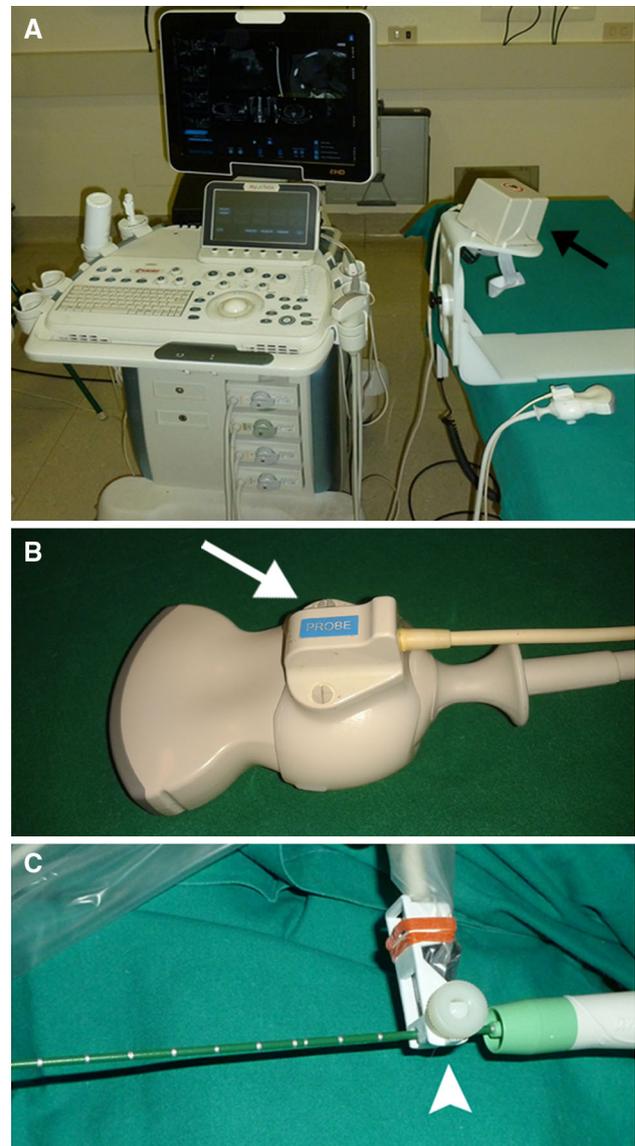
Virtual navigation system for real-time US-CT/MRI image fusion. The system is made of an US scanner (MyLab Twice, Esaote, Genova, Italy) with a dedicated built-in hardware and software (Esaote, Genova). An electromagnetic tracking system integrated in the workstation consists of a magnetic field transmitter (*black arrow*, A), fixed to the operation bed at the right upper quadrant of the abdomen, and two electromagnetic sensors, one applied to the convex ultrasound probe (*white arrow*, B), and one mounted on ablation applicator (*arrowhead*, C)
